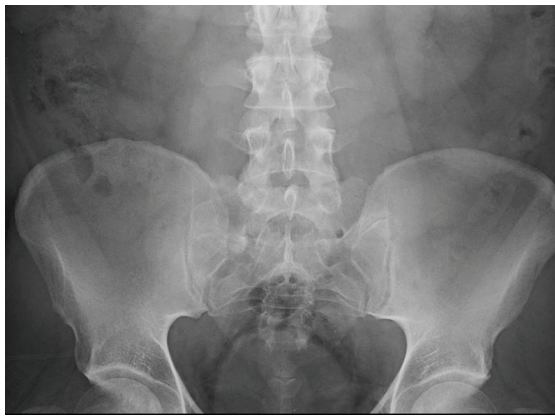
Pelvic radiograph, transverse mega-apophysis view of the L5 vertebra articulating with the bilateral sacral ala
